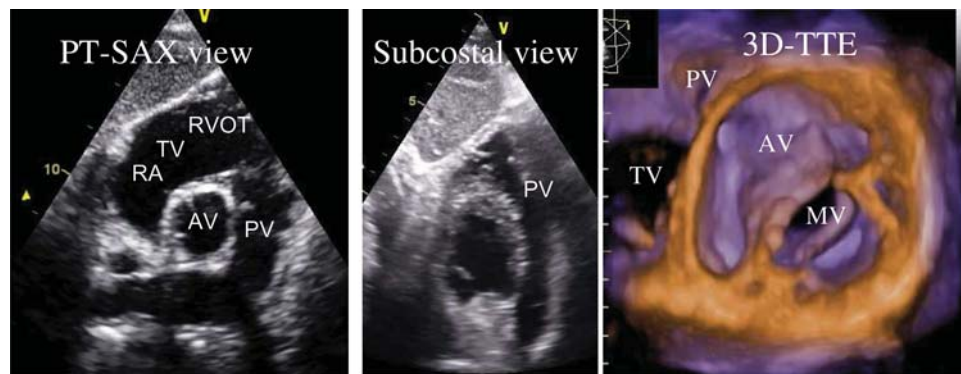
Two- and three-dimensional echo recordings of the pulmonic valve. PT-SAX, parasternal short-axis view.
